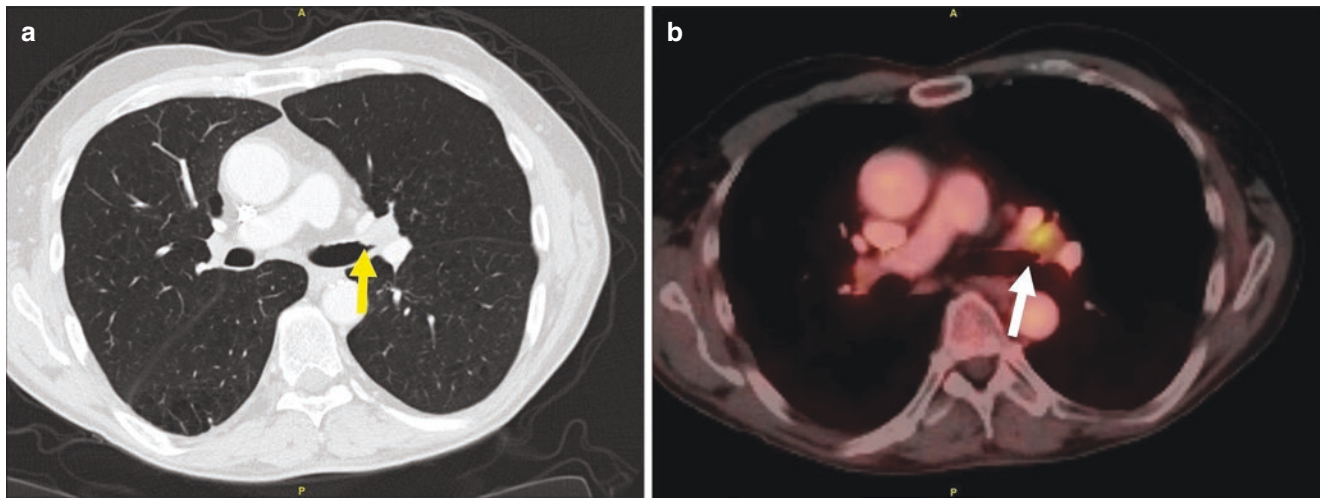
Radiologic findings in lung squamous cell carcinoma. (a) CT with contrast demonstrated an enhancing, endobronchial mass (arrow). (b) PET-CT demonstrating FDG-avidity of the endobronchial mass (arrow)
